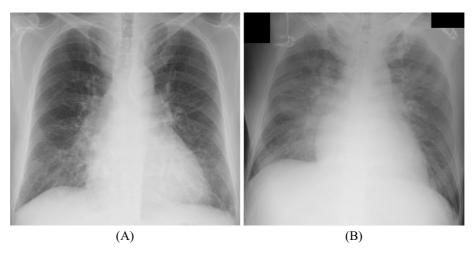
A comparison between chest radiography performed at admission (A) and that performed after the anaphylaxis reaction (B). Both (A) and (B) show an increased cardio-thoracic ratio. In addition, (B) shows bilateral hilar expansion and congestion in both lung fields.
